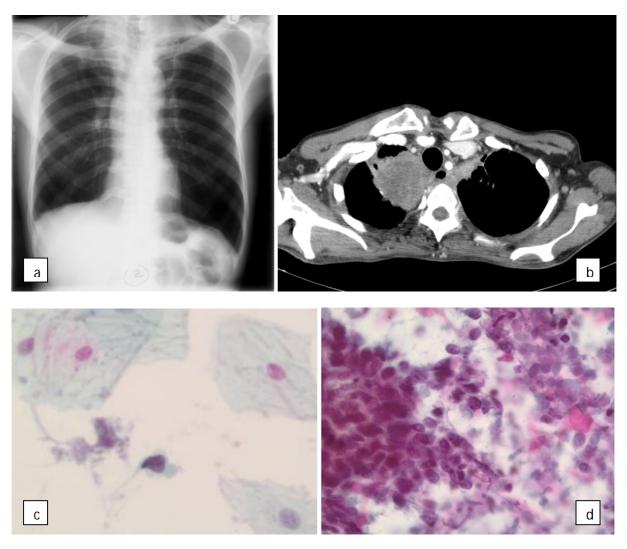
Bilateral Pancoast tumours with destruction and erosion of vertebral bodies and ribs on chest X-ray (a) and CT (b). Sputum - suspicious for malignancy. Sparse spindled cells present with irregular nuclei (c). TTNA - Squamous cell carcinoma with keratinised necrotic debris (d).
